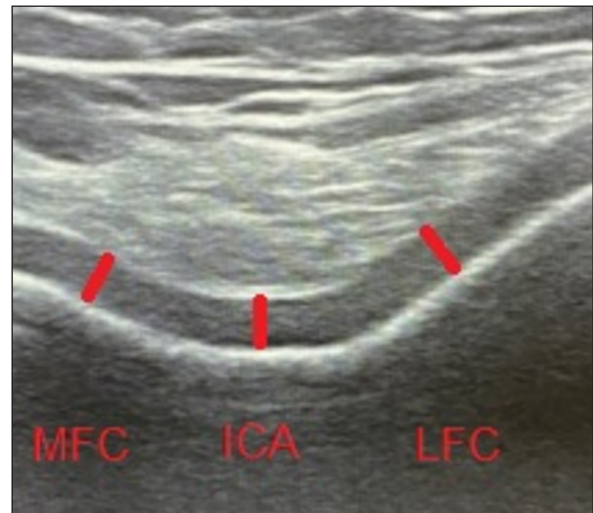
Ultrasonographic appearance of left knee femoral cartilage with normal thickness and smooth surface, from 45 years old female nondiabetic. (MFC: medial femoral condyle, ICA: intercondylar area, LFC: lateral femoral condyle).
